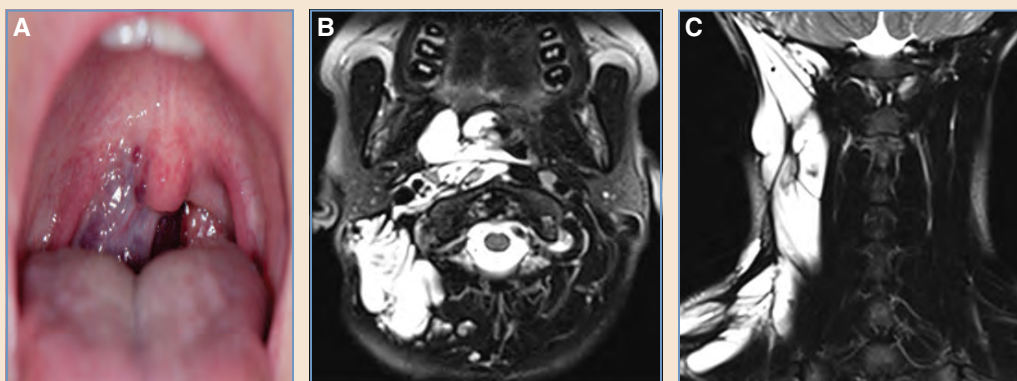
Orocerivopharyngeal venous malformation. A, A teenage girl with hemoptysis from a right-sided oropharyngeal venous malformation. Clinical examination showed obvious right-sided blue venous malformation. The full extent of the disease was not appreciated until the MRI scan was done, because she had no symptoms related to her neck and no cervical abnormality on physical examination. B and C, MRI showed an extensive soft tissue venous malformation in the oropharynx abutting the airway, with intramuscular extension throughout the right neck.
